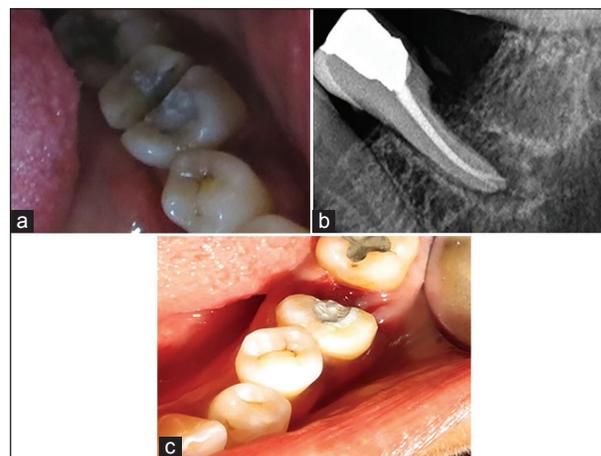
(a) Initial cut during sectioning procedure (b) Post sectioning radiograph (c) Clinical view of sectioned tooth
